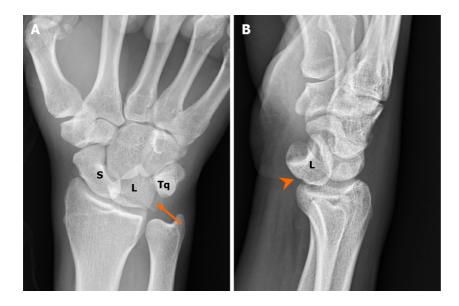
A 37-year-old man with multiple traumas. Radiological examinations revealed acute lunate dislocation with triquetral fracture. A: Plain radiograph in the emergency department showed triangular appearance of the lunate (piece of pie) with triquetral fracture. Note the avulsion of the triquetrum (arrow) due to failure of the lunotriquetral ligaments; B: Lateral view of the radiograph showed volar dislocation of the lunate bone (arrowhead). S: Scaphoid, L: Lunate, Tq: Triquetrum.
